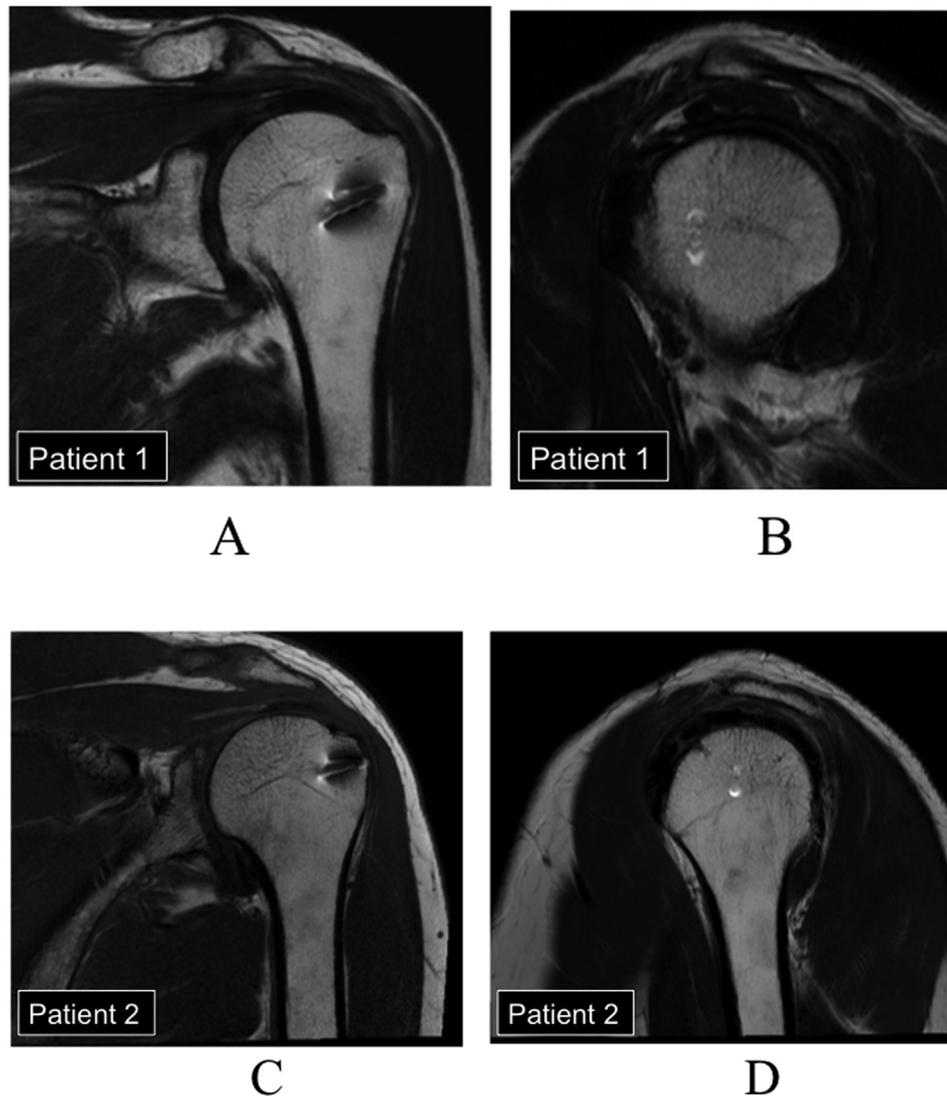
Coronal T2-weighted MRI 3 months after arthroscopic knot removal. (a) Coronal image in patient 1. (b) Sagittal image in patient 1. (c) Coronal image in patient 2. (d) Sagittal image in patient 2. In both patients, the subacromial effusion has disappeared and the repaired supraspinatus tendon has healed.
